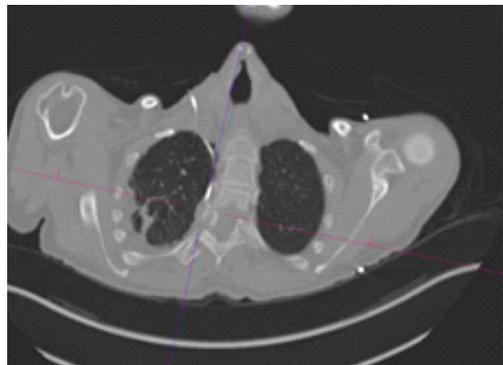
Axial CT cut in lung window demonstrating central line misplaced with tip in right pleural cavity
